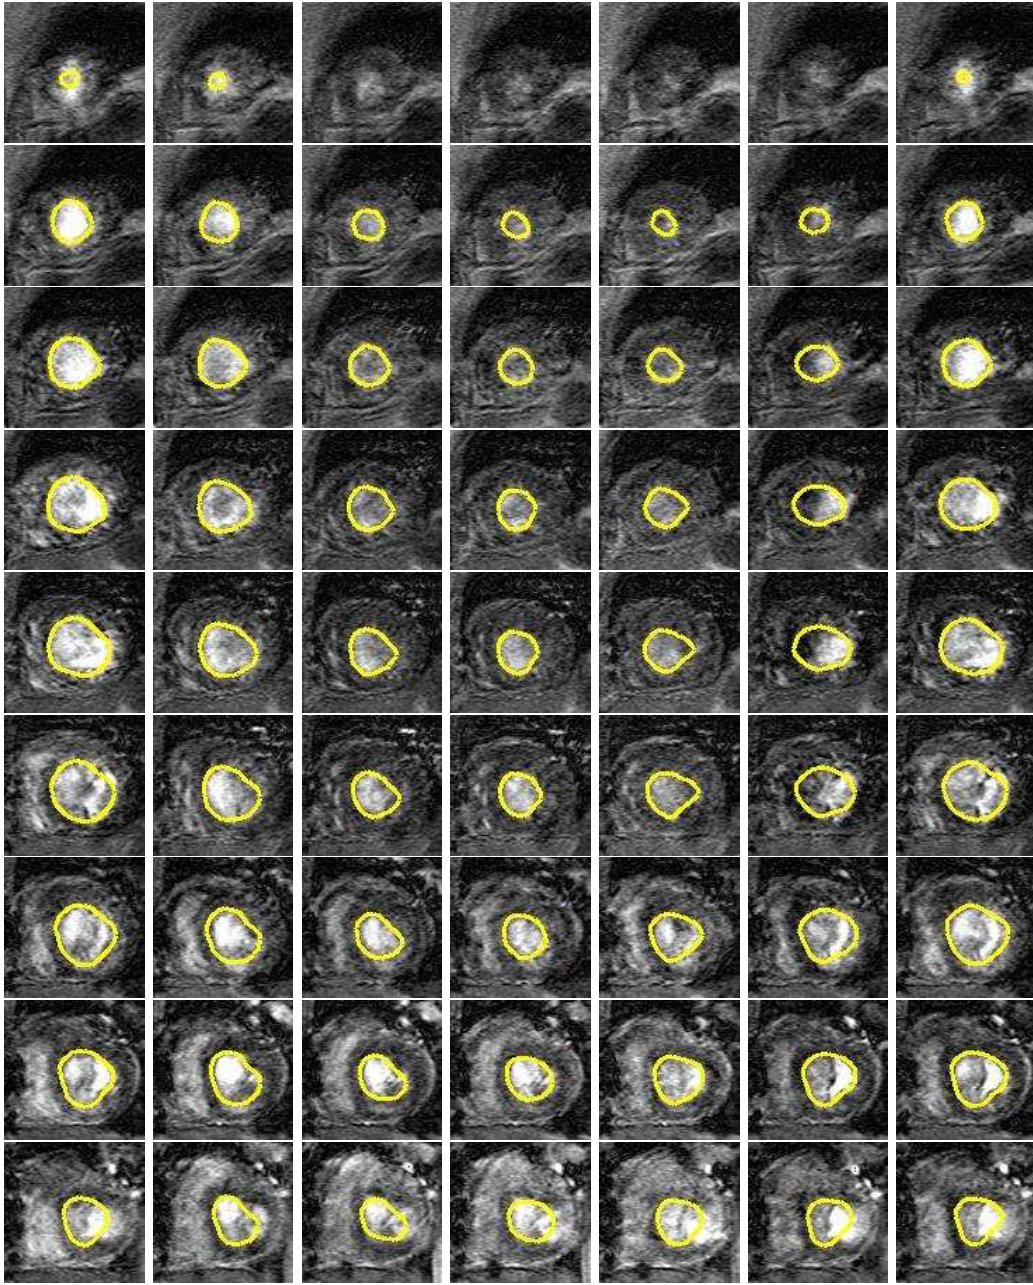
Reconstructed 4D model superimposed in the original MRI slices. Each line represents the time sequence of one slice of the 3D image while each column represents the set of slices composing a 3D image at one instant.
